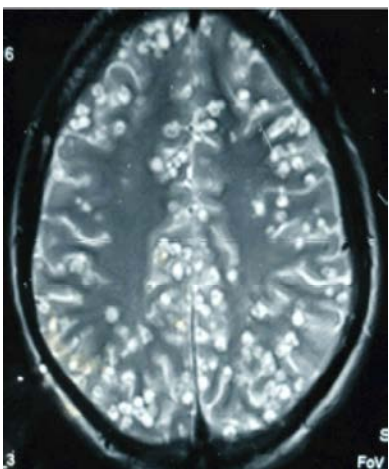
T-2 MRI axial view showing Racemose NCC
